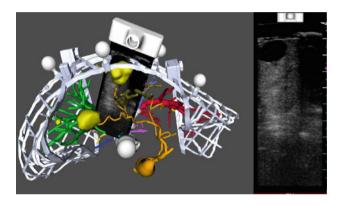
Navigation interface showing a joint display of the three vessel systems of the liver, tumors, the 3D mesh and the ultrasound probe and image, together with a larger view of the ultrasound image
